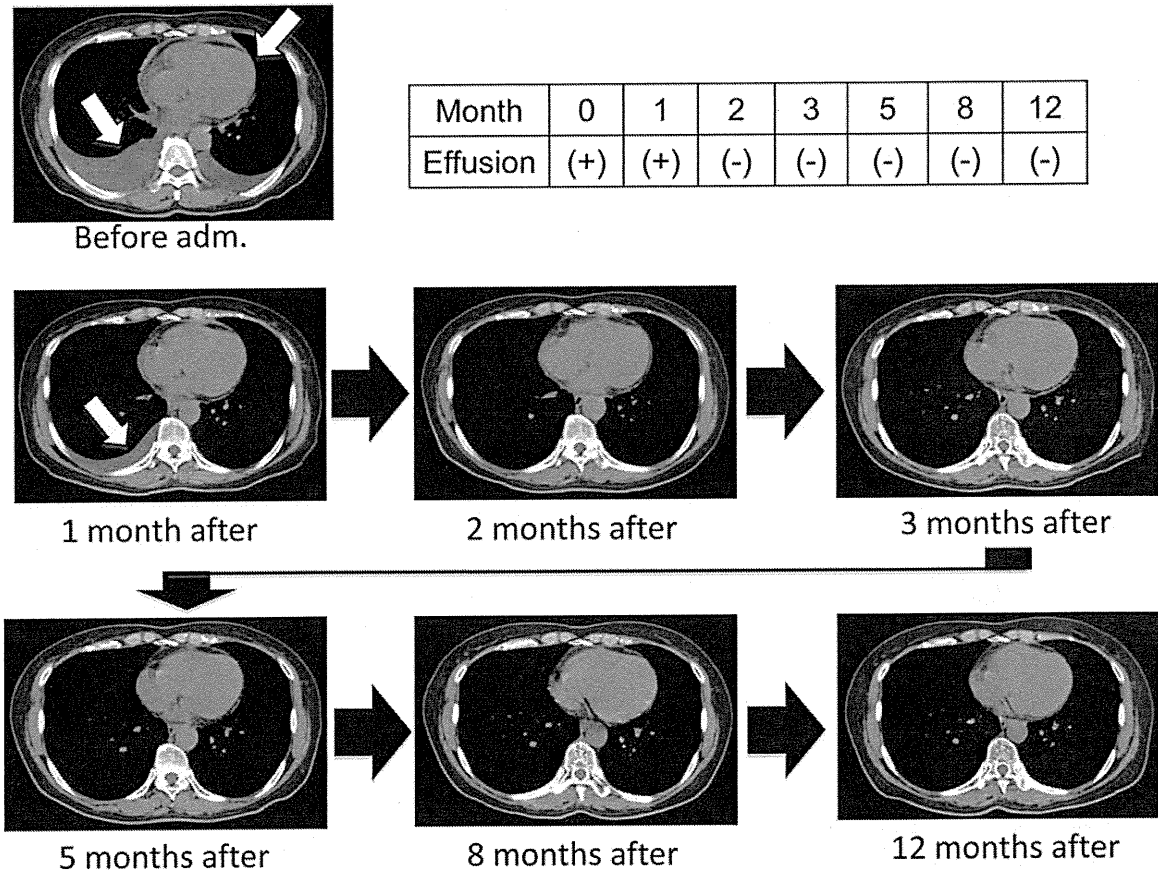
Computed tomography of the patient before, during and after treatment. White arrows indicate pleural and cardiac effusion.
